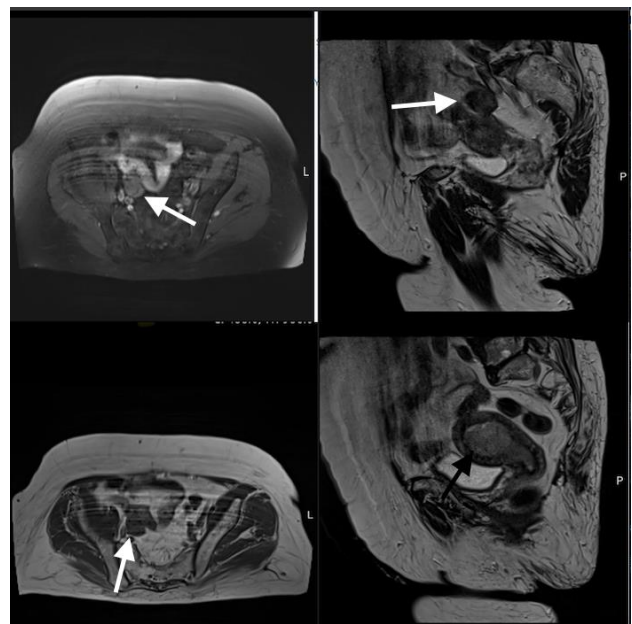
Axial and sagittal pelvic MRI image. The white arrows indicate a heterogeneous solid adnexal mass. The black arrow points to the irregular endometrial thickening compatible with endometrial carcinoma.
